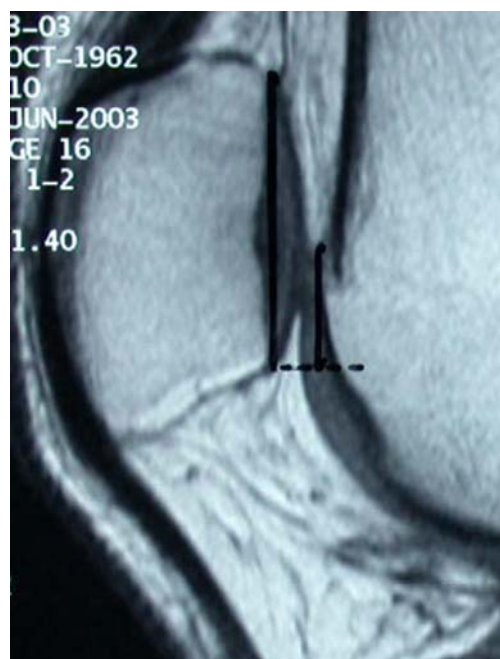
Measurement of the patellochlear index on sagittal MRI
